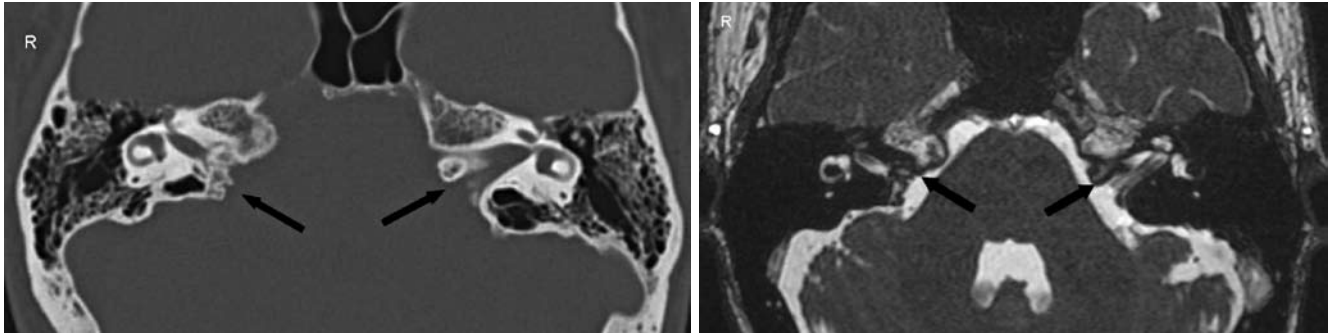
A. CT Scan, axial image. Bilateral stenoses of internal auditory canal (black arrows). B. T2-weighted MRI axial image showing bilateral stenosis of the internal auditory canal (black arrows).
